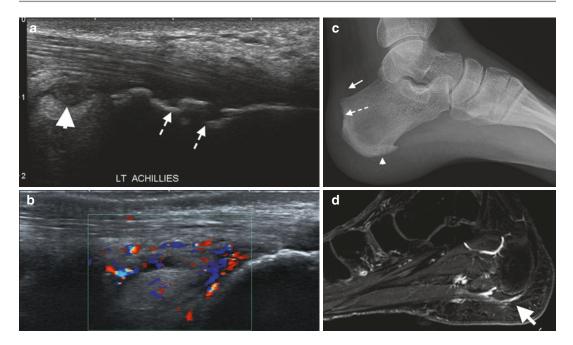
An 18-year-old male with a 2-year clinical history of unresponsive distal Achilles tendinosis. (a) Longitudinal ultrasound with erosions of the calcaneus (*dashed arrows*) and distended retrocalcaneal bursa which demonstrates marked flow on color Doppler (b), also noted within distal tendon. (c) Lateral ankle radiograph demonstrating erosions of the calcaneus (*dashed arrow*), soft tissue thickening in the region of retrocalcaneal bursa
